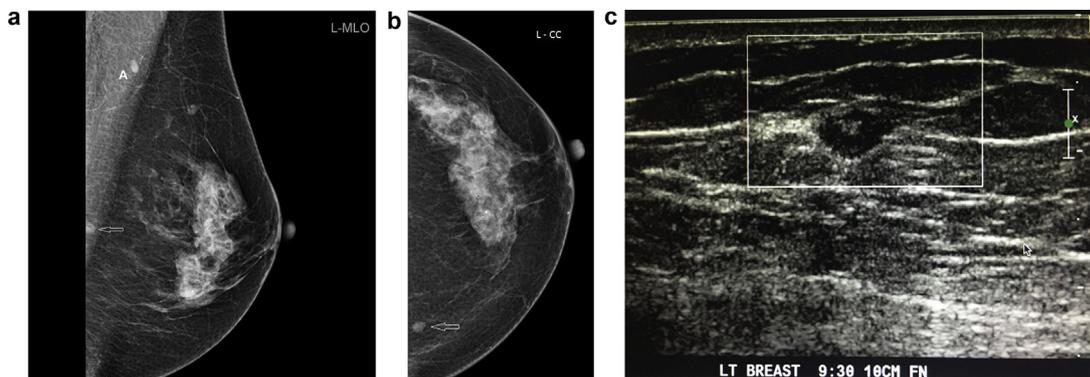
Screening mammogram (a and b). (a) left breast – MLO. (b) left breast – CC. A new small circumscribed opacity is noted in the left breast at approximately 9 o'clock 10 cm from the nipple (arrows). Apart from a small normal appearing lymph node (marked A), no other new lesions were seen. [Reviewer Point 4]. (c) (Ultrasound) – A single targeted B-mode ultrasound image of the left breast with colour doppler assessment demonstrates a small solid avascular hypoechoic nodule with a tiny internal hyerechogenic foci. The lesion did not demonstrate any suspicious features, and correlates with the small circumscribed lesion noted on the mammography.
